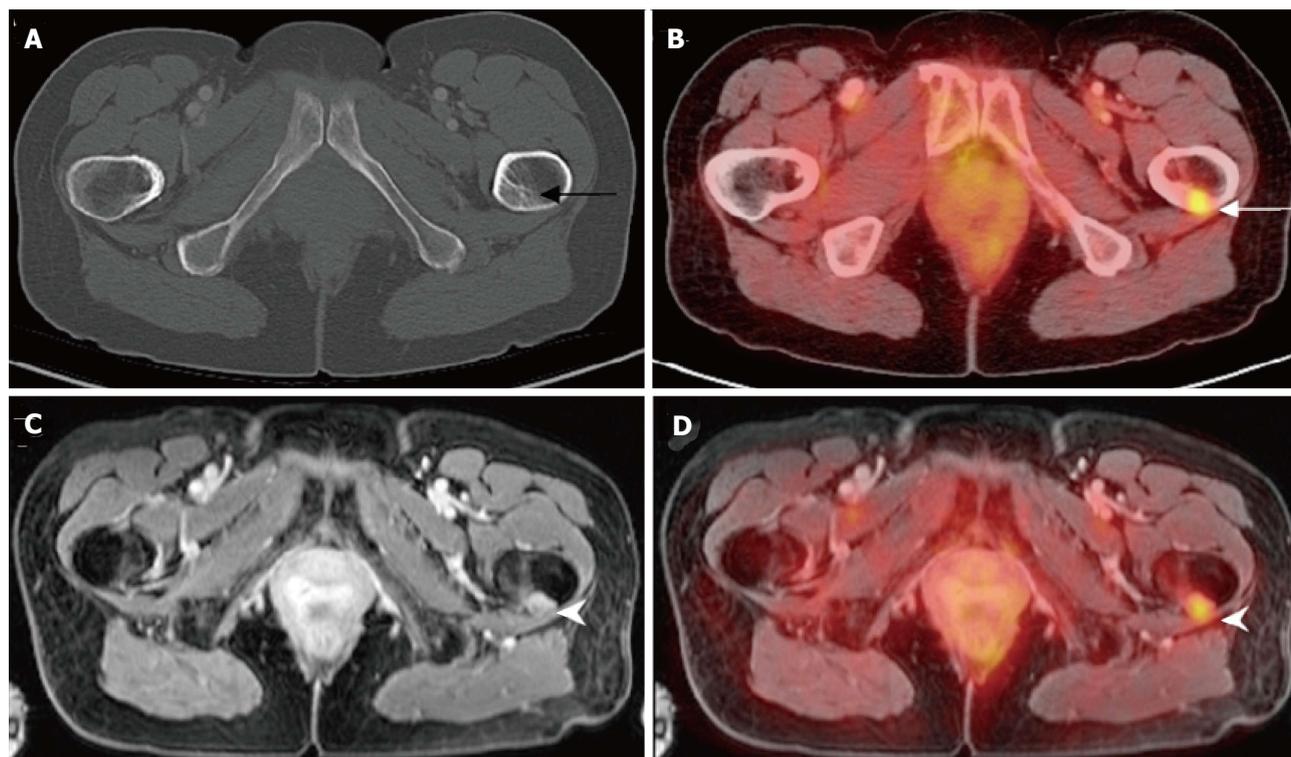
A 59-year-old female with history of breast cancer status post resection and chemoradiation presents with left hip pain. Noncontrast CT of the pelvis (A) was unremarkable. PET/CT revealed increased focus of FDG uptake within the proximal left femur. Contrast-enhanced pelvic MRI (C) and PET-MRI (D) acquired simultaneously demonstrates abnormal nodular soft tissue mass within the proximal left femoral cortex with increased radiotracer uptake compatible with metastasis in this patient with breast carcinoma. PET: Positron emission tomography; MRI: Magnetic resonance imaging; CT: Computed tomography; FDG: ¹⁸F-fluorodeoxyglucose.
